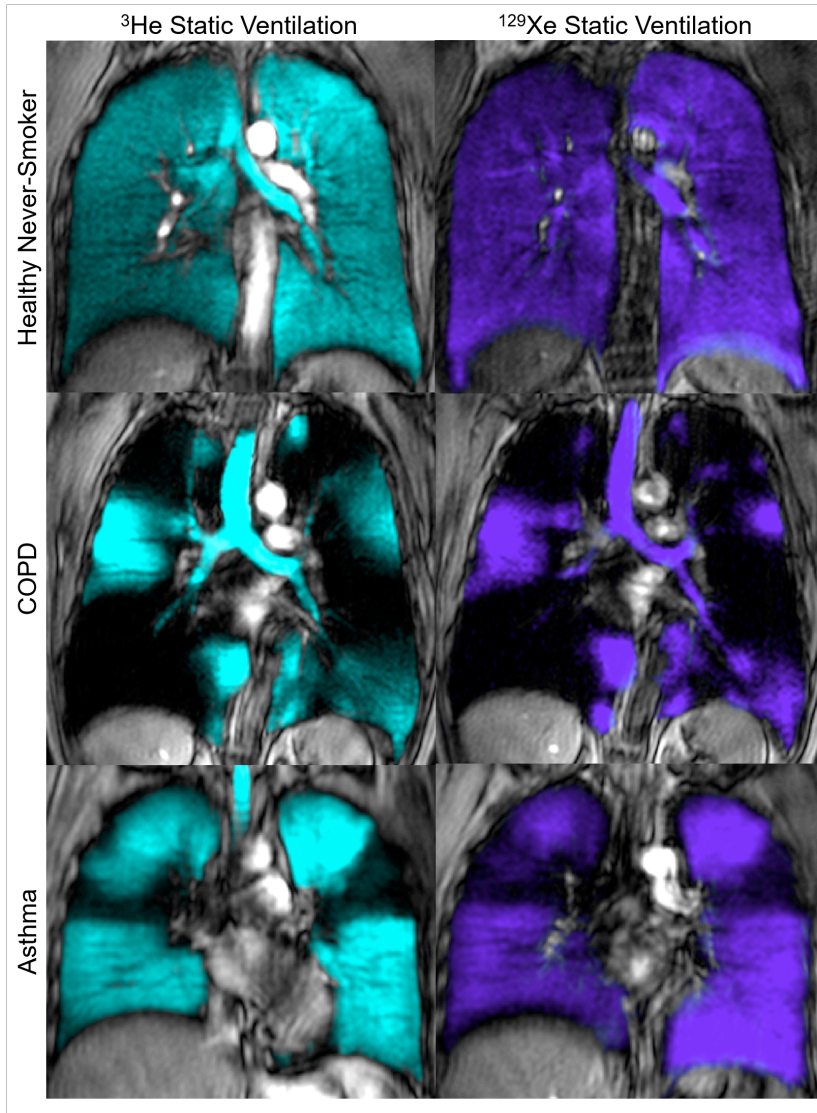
Static Breath-hold ^3He and ^{129}Xe Ventilation MRI
